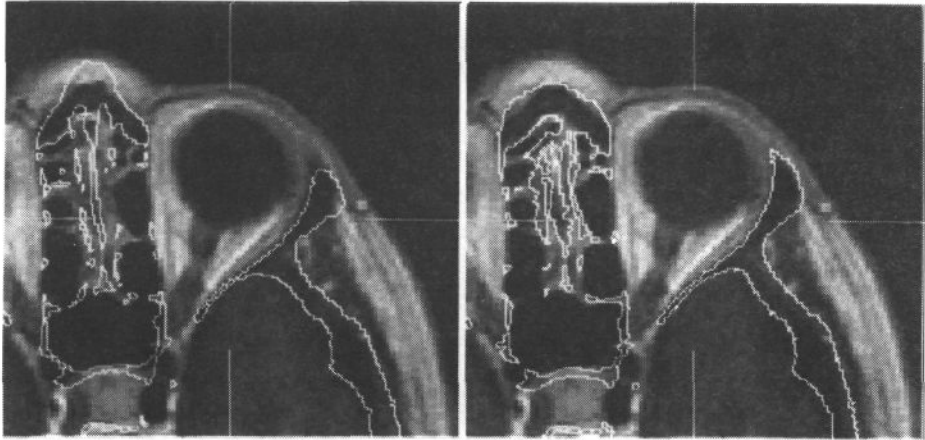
Images showing transaxial slices through the eye in the MR volume for patient C with CT bone threshold boundary in white for the manual registration estimate (left) and the estimate from minimisation of corresponding MR variance (right).
